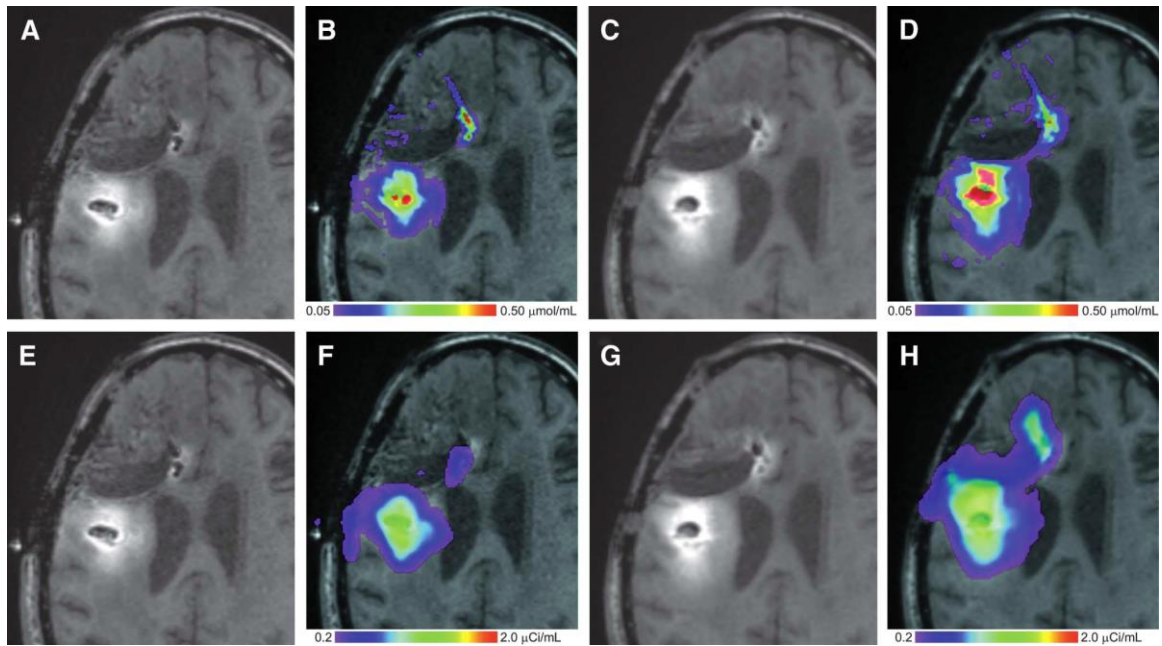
A-D, T1-weighted MRI signal (A and C) compared with measured Gd-DTPA concentration profile (B and D). E-H, T1-weighted MRI signal (E and G) with overlaid ^{124}I -HSA concentration (F and H).
